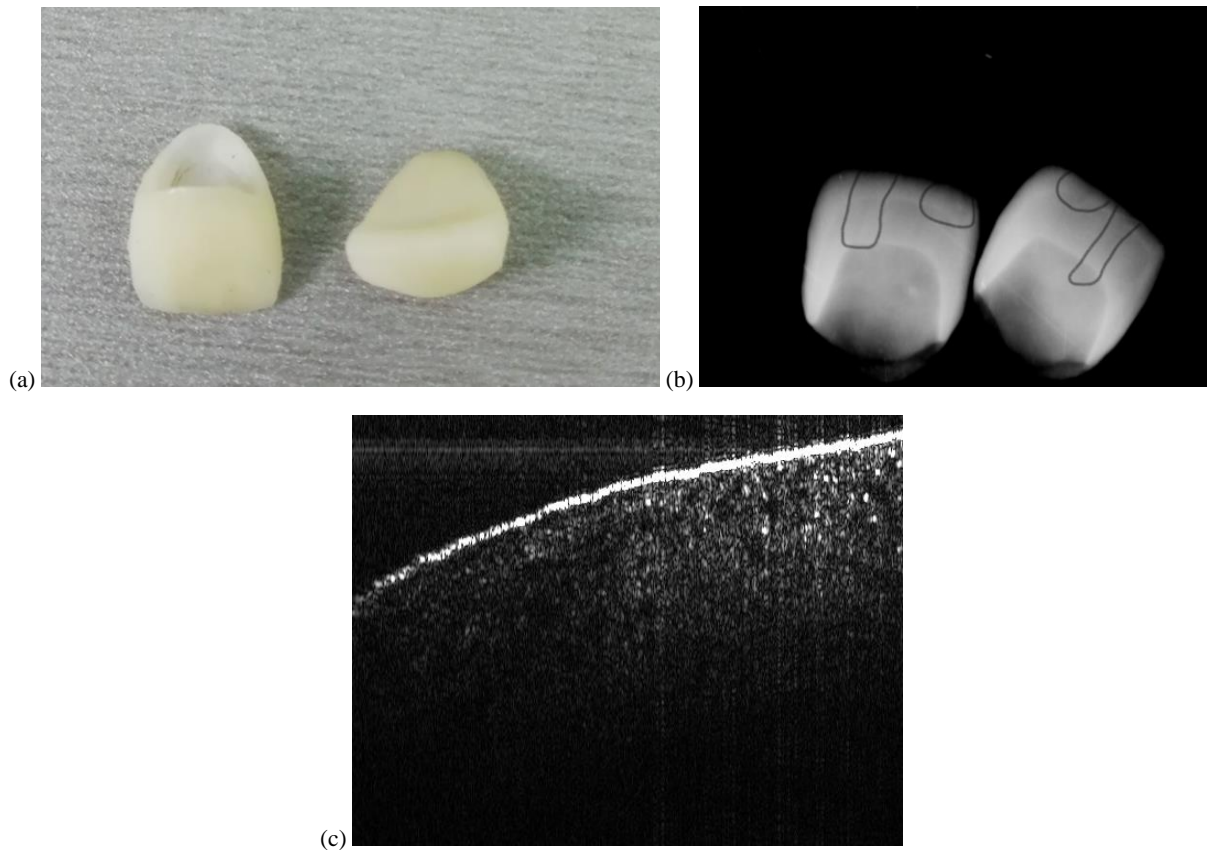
(a) Examples of zirconia dental crowns. (b) Radiographs of the zirconia dental crowns from (a). (c) OCT B-scan of a zirconia dental crown from (a).
